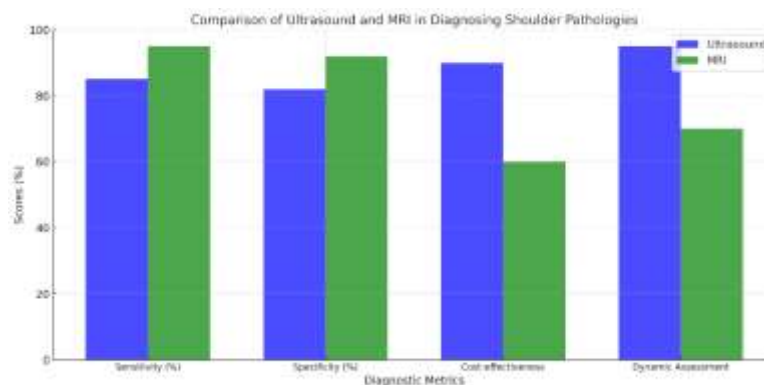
Comparison of Ultrasound and MRI in Diagnosing Shoulder Pathologies
